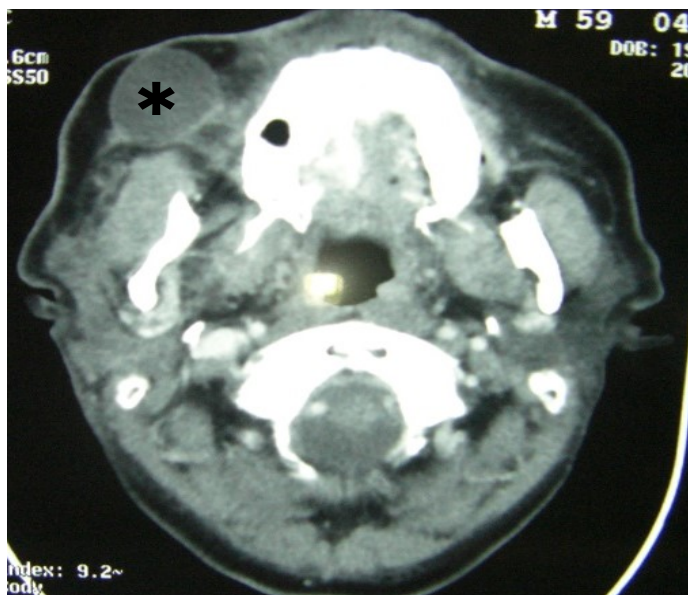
CT scan demonstrated a 2X3cm cyst (arrow) in front of a masseter muscle (asterisk).
